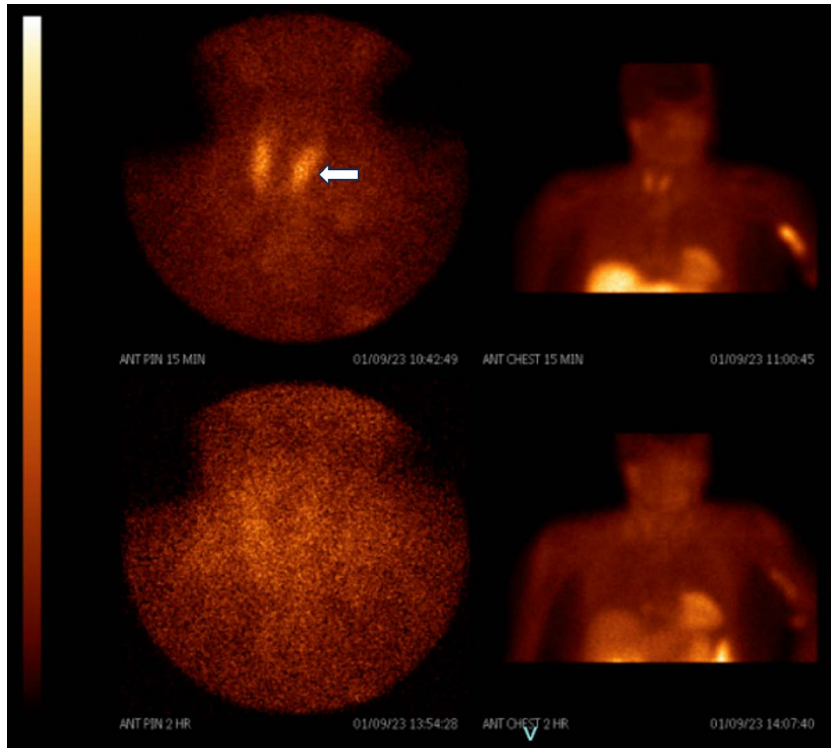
Coronal Planar SPECT, images of a ^{99m}Tc-sestamibi (MIBI) scan, demonstrate physiologic symmetric thyroid glandular radiopharmaceutical uptake and wash-out without abnormal parathyroid activity. This a false-negative MIBI study in a pathologically confirmed case of parathyroid carcinoma. Note the medial displacement of the left thyroid lobe (arrow).
